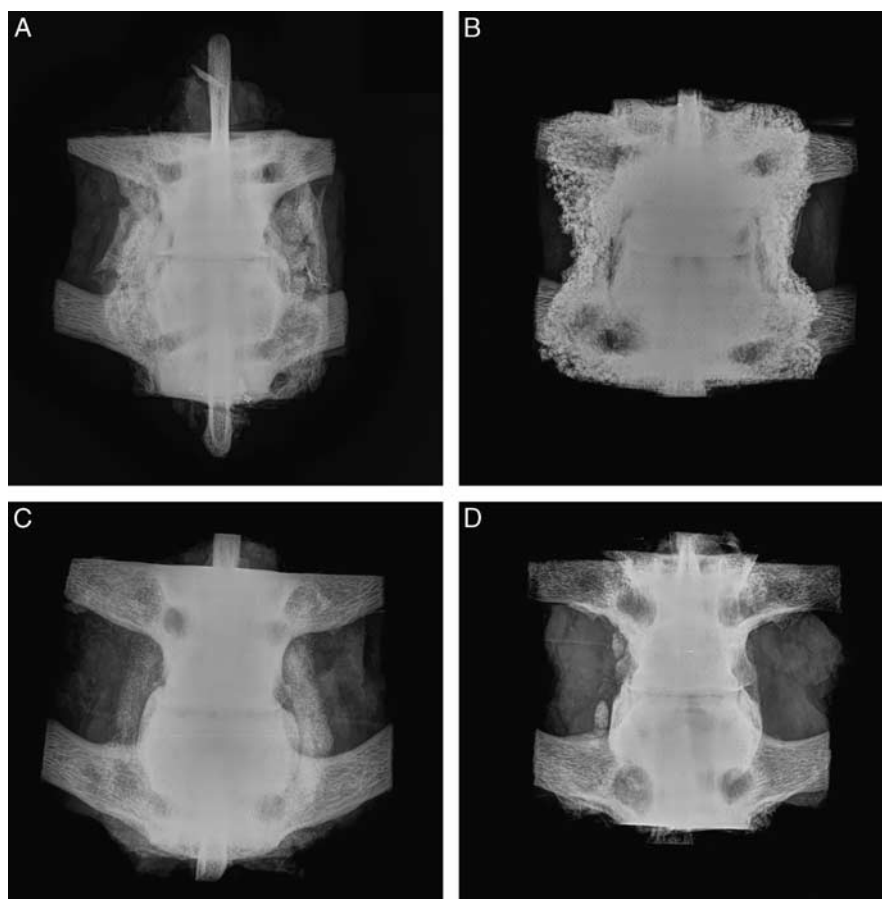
Representative examples of faxitron radiographs of the spinal levels treated with AB (A), BCP_{<μm} (B), BG (C), and TCP/BG (D), after removal of instrumentation. AB indicates autograft bone; BCP_{<μm}, biphasic calcium phosphate with submicron topography; BG, Bioglass; TCP, tricalcium phosphate.
